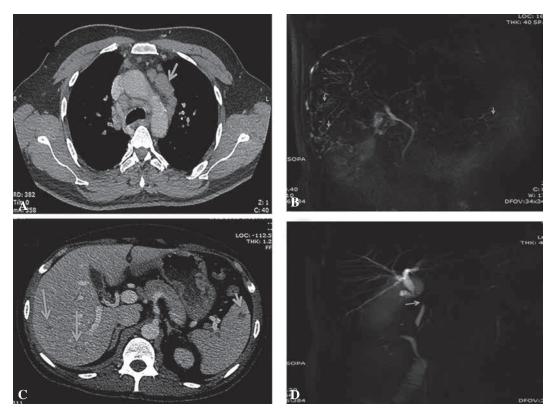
Imaging: 3A: Axial contrast-enhanced computed tomographic image of chest at the level of arch of aorta (upper) demonstrating multiple enlarged mediastinal lymph nodes; 3B: Axial contrast-enhanced computed tomographic scan of abdomen (lower) showing few well defined subcentimeter sized hypodense non-enhancing nodular lesions involving both liver (long arrow) and spleen (short arrow); 3C: Two-dimensional magnetic resonance cholangiopancreatographic image showing skip areas of dilatation and narrowing involving bilobar intrahepatic biliary radicals giving them a beaded appearance (arrow); 3D: Two-dimensional magnetic resonance cholangiopancreatographic image showing stricture involving the suprapancreatic common bile duct (arrow).
